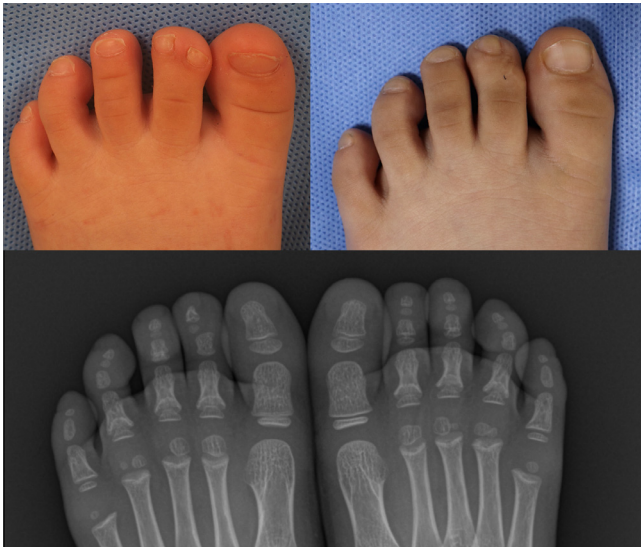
A patient (16 months of age) with central polydactyly of the toe presented with ‘eyes of a bird’ nail deformity. Seventy-nine months after rotational osteo-onychocutaneous flap procedure, the main digit showed no residual angulation nor rotational deformity. Radiographically, the ossification of distal phalanx was hypoplastic when compared to that of the contralateral side, but its deformity was not significant.
